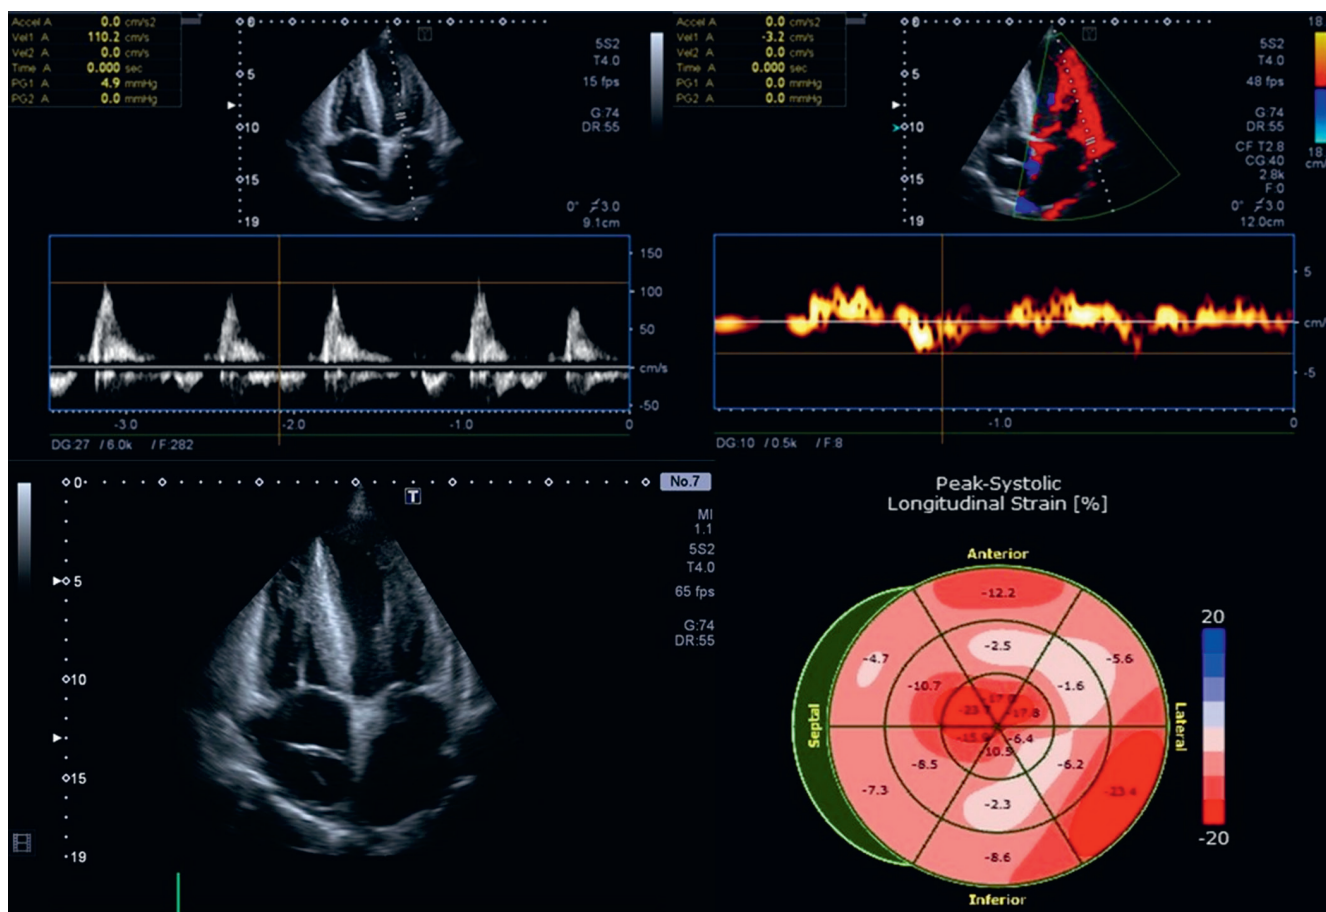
Echocardiogram of a 57-year-old patient with multiple myeloma and light-chain cardiac amyloidosis (AL-CA): concentric myocardial hypertrophy; the thickening of the valve apparatus; atrial enlargement; pericardial fluid; an increased filling pressure ($E/e' = 30$); and apical sparing
